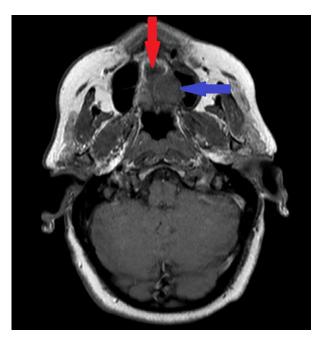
Axial view of T1 MRI scan demonstrating soft-tissue mass extending from the hard to the soft palate on the left side (blue arrow). It also appears to cross the midline with extension into the nasal cavity (red arrow).
